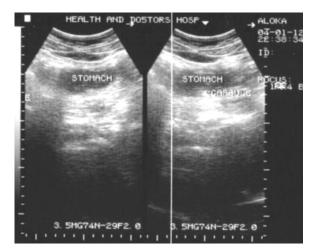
Ultrasonogram images of Formulation F3 at 15 minutes.
